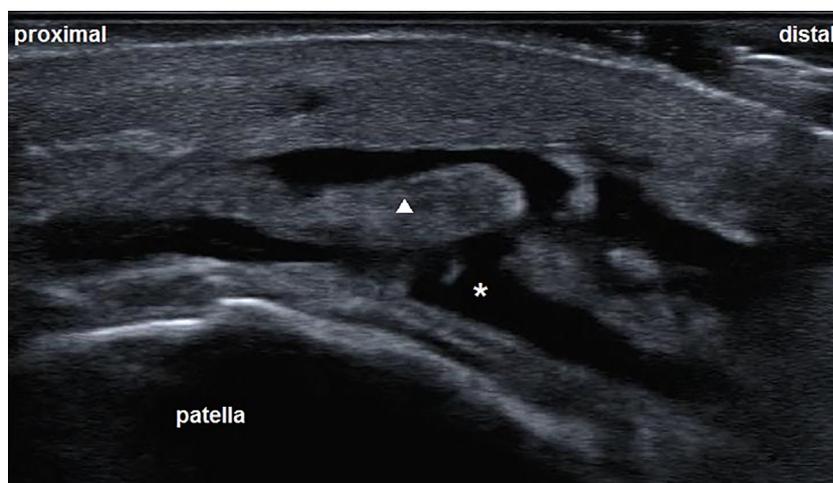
Ultrasonography in a patient with prepatellar septic bursitis, longitudinal view: note the anechoic bursal effusion (asterisk) and synovial lining hypertrophy (arrowhead).
